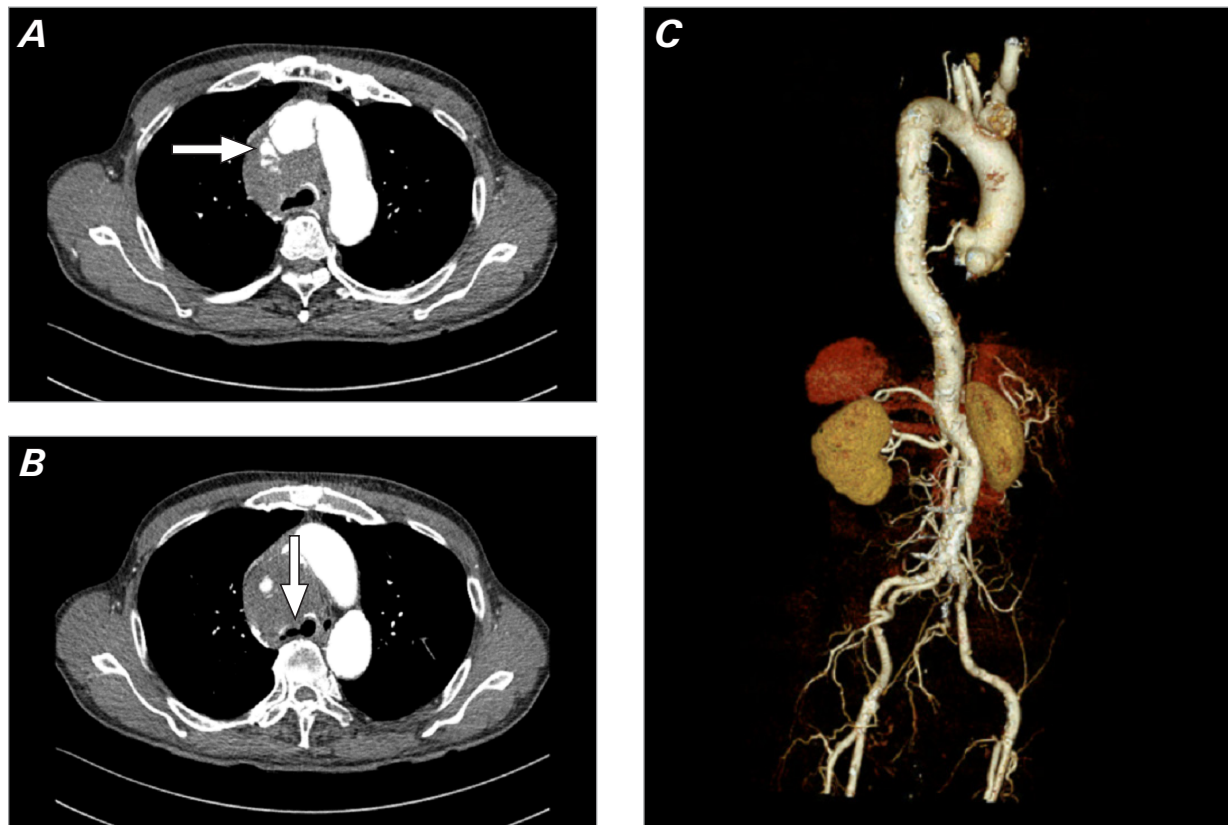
Preoperative computed tomograms show (A) an aortic aneurysm measuring $8 \times 6 \text{ cm}^2$ at the origin of the brachiocephalic artery, with a small volume of contrast media leakage (arrow) and (B) an aortic aneurysm causing tracheal compression (arrow). (C) A preoperative 3-dimensional computed tomogram shows a saccular aortic aneurysm.
